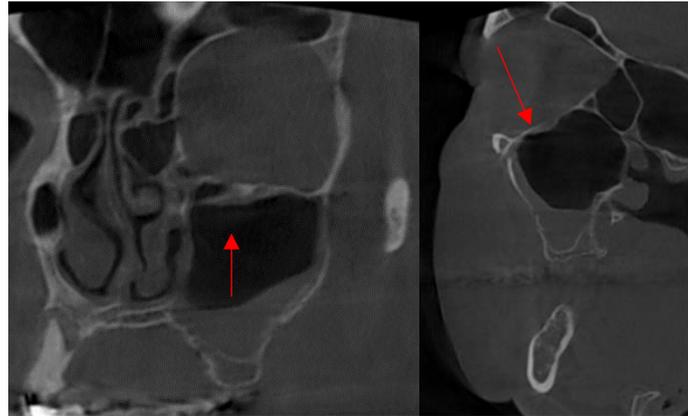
Individualized. coronal oblique (a) and sagittal oblique reconstructions (b) for the left orbit using CBCT. (c) Fracture of the infraorbital wall's internal third, with minor hemosinus and (d) intra sinus hernias of adipose tissue from the orbit.
